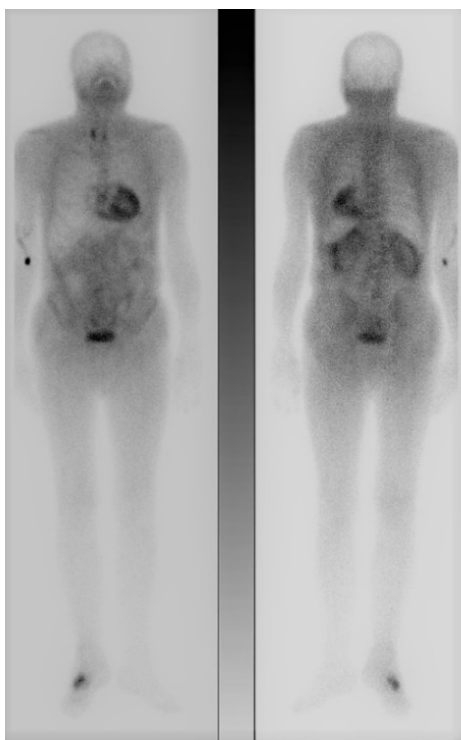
Whole body scintigraphy with ^{99m}Tc -DPD in the anterior and posterior projection. Qualitative assessment corresponding to Perugini score of 3.
